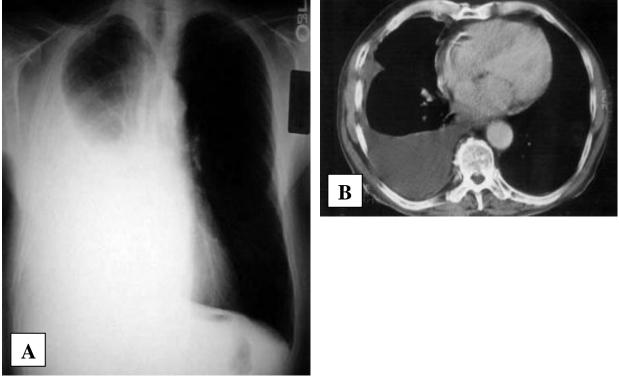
A. Right pleural effusion of malignant etiology. B. Medium sized right pleural effusion evidenced by the CT scan of the thorax
